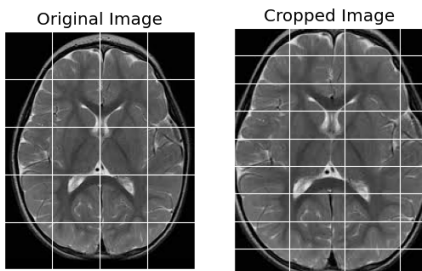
Original Brain MRI Image with Tumor Not Assessed
